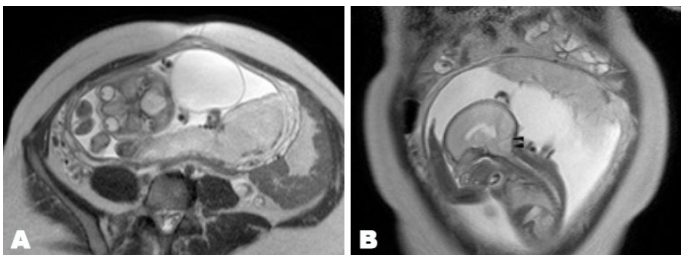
(A) Axial and (B) sagittal T2-weighted imaging demonstrating a small appearing posterior fossa, but no tonsillar herniation or other anomalies.
